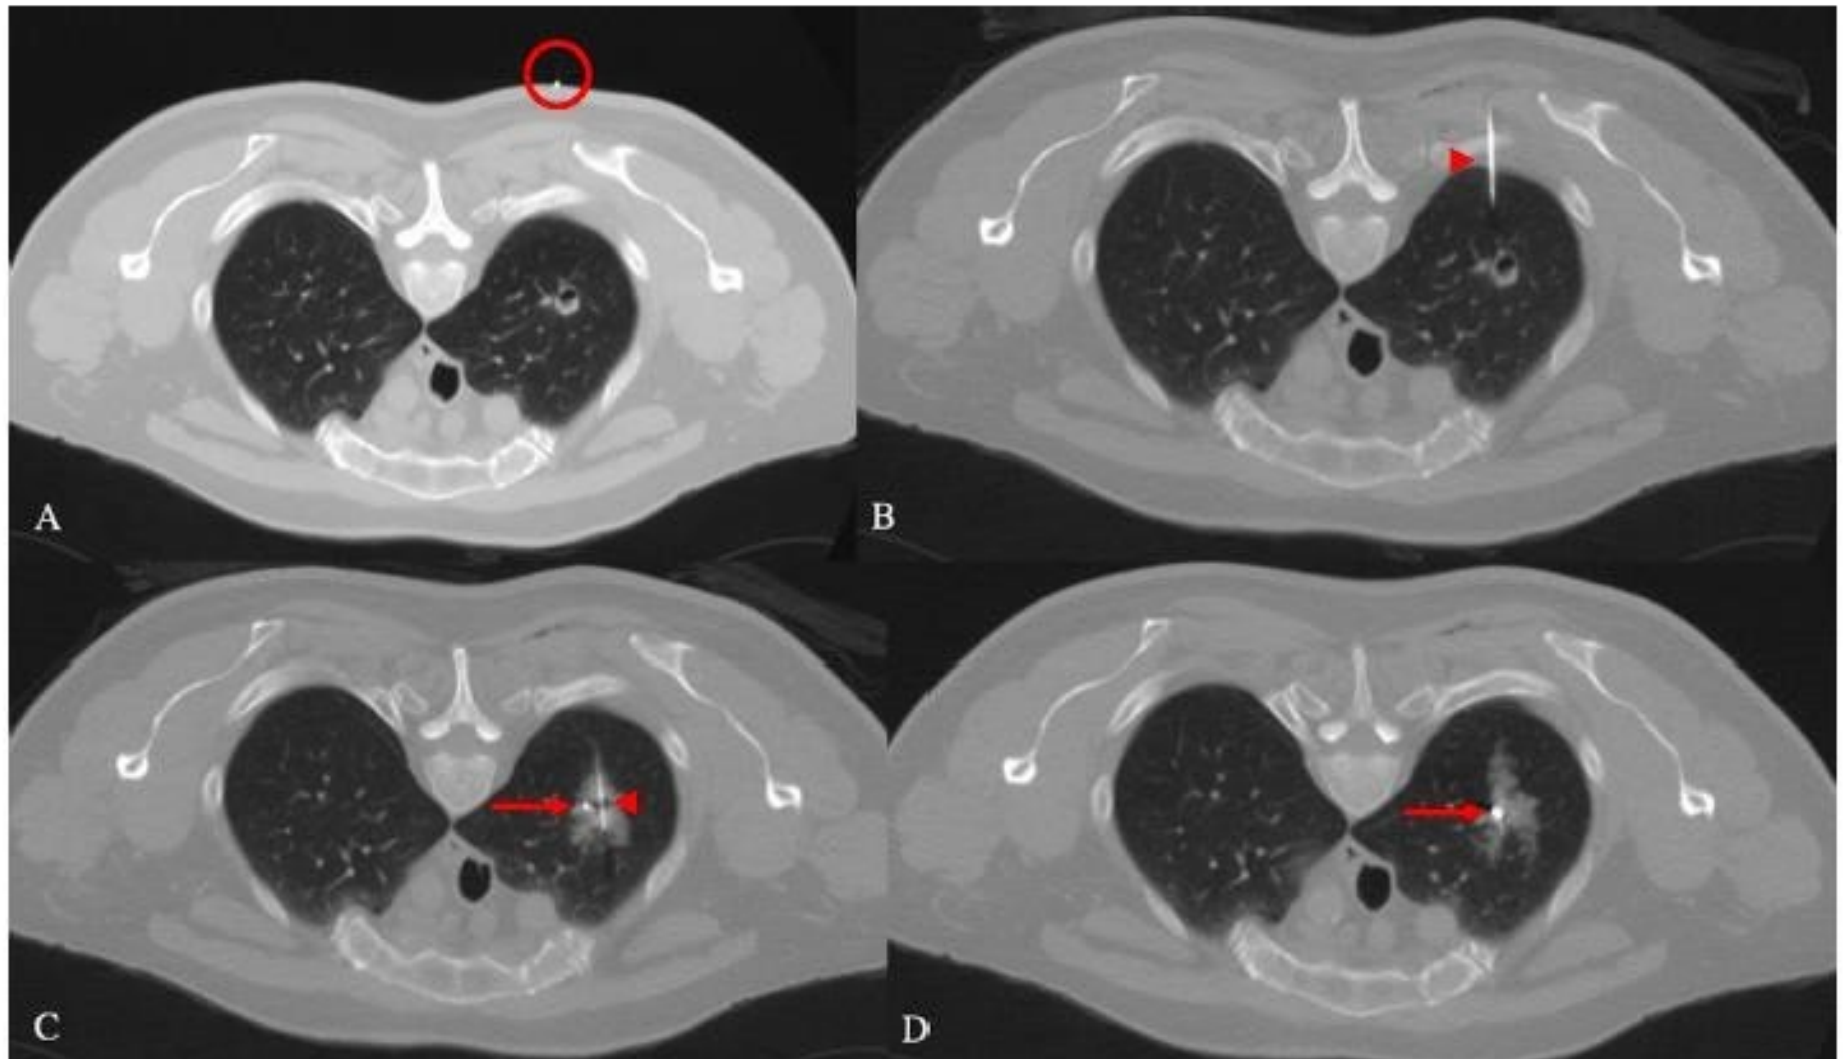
CT-guided Lung Nodule Fiducial Marker Placement and Biopsy
